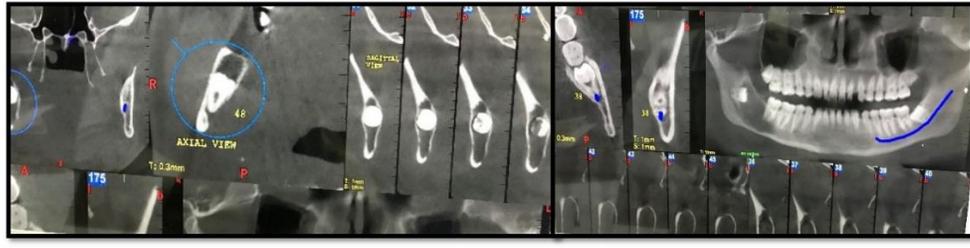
Cone beam tomography sections reveal a radiolucency in the region of mandibular third molar.
